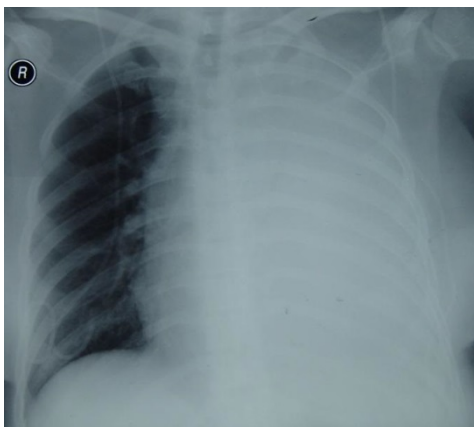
Hydrothorax at the left lung and bilateral shunt images can be seen in posteroanterior lung direct radiography.
